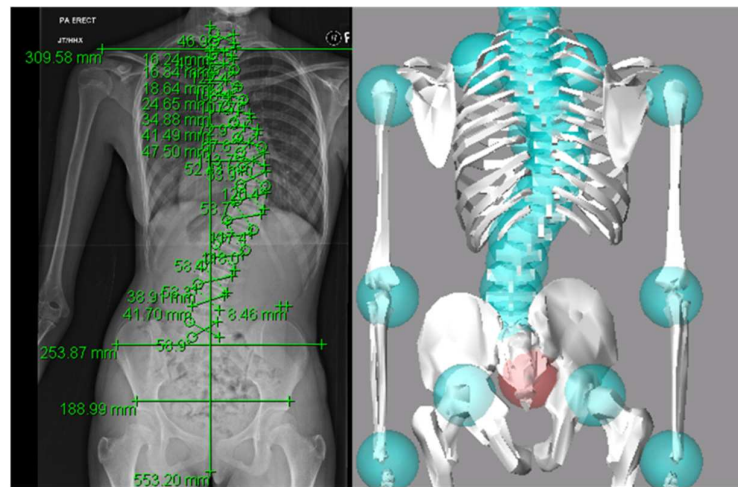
The scoliotic spine model which created based on the X-ray images
